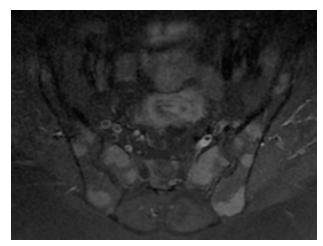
Axial T1FS MRI with contrast media: enhanced nodular lesions of the sacral and iliac parts.
